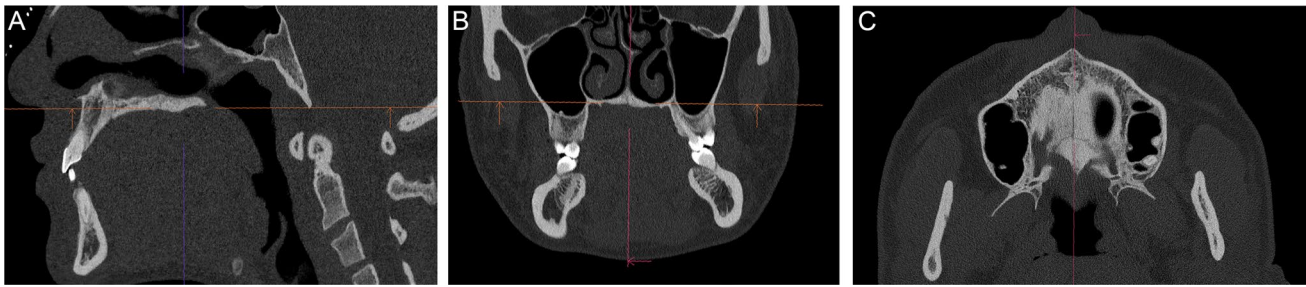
Standardized alignment of the CT data set in A) the sagittal, B) the coronal, and C) the axial slices according to previously defined reference lines and reference points. The following parameters were measured in the respective slices: A) sagittal slice: palatal length; B)
